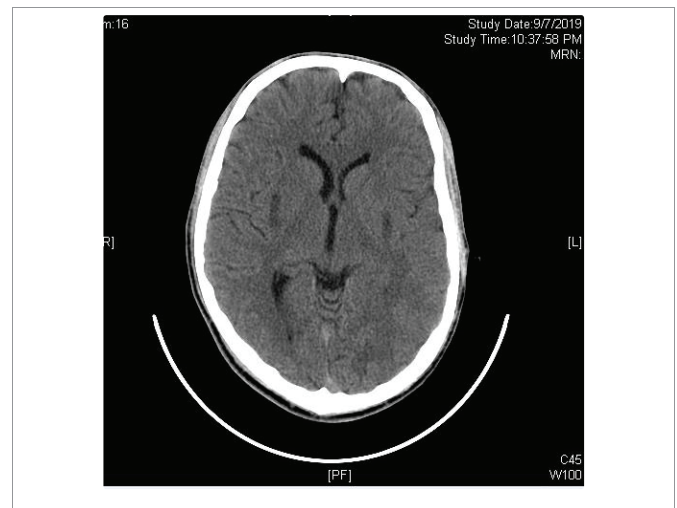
CT brain on admission: Bilateral putamen hypodensities.
